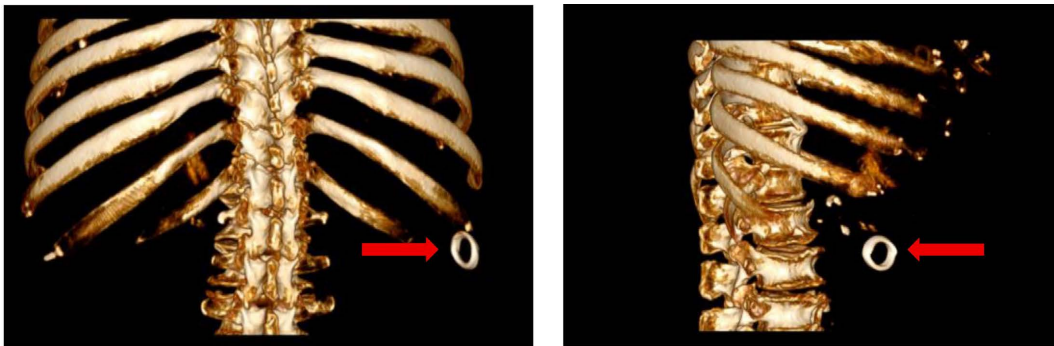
Three-dimensional CT imaging, where the arrow marks the IUD
